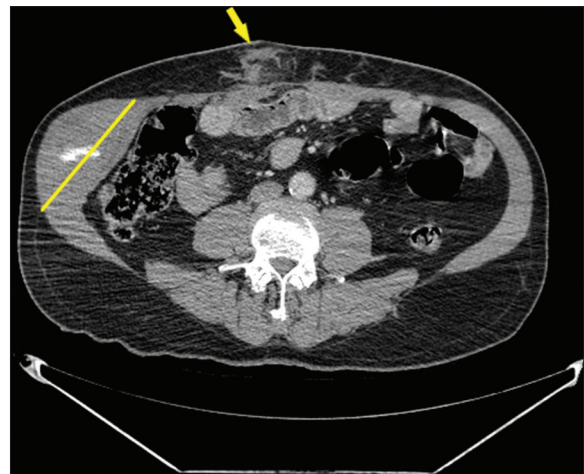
The yellow line indicates the hematoma area, and the yellow arrow indicates the peri-umbilical stab wound area on the axial plane of the CT scan. CT: Computed tomography
